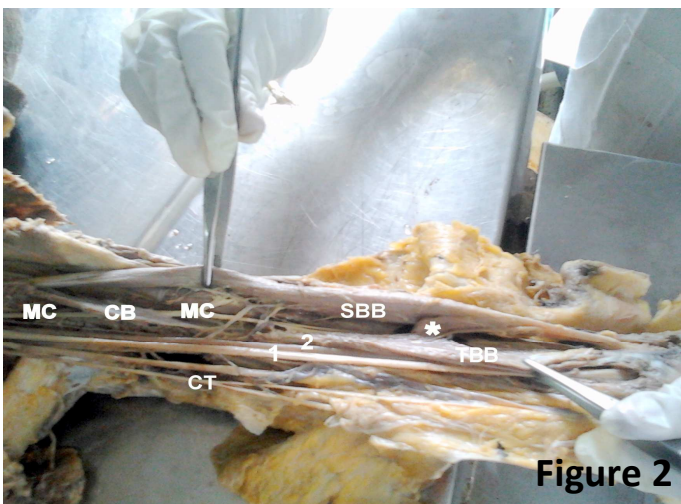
showing musculocutaneous nerve piercing the slender coracobrachialis and the medial positioning of median nerve to brachial artery in the left upper limb. MC – musculocutaneous nerve, CB – coracobrachialis muscle, SBB- short head of biceps brachii, TBB – third head of biceps, * - accessory muscle fascicle, 1 – median nerve, 2 – brachial artery, CT – common trunk for medial cutaneous nerve of arm and forearm.
